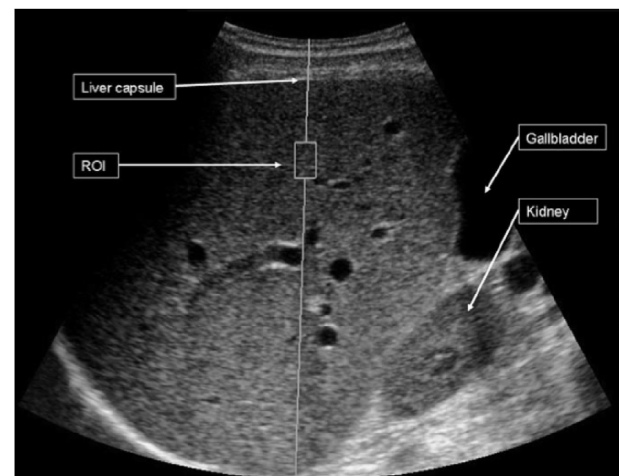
Acoustic radiation force impulse is used to measure shear waves; its major advantage over tissue elastography is that it can be used in conjunction with conventional ultrasound and shear wave velocity to gauge liver stiffness [9]. ROI = region of interest.
